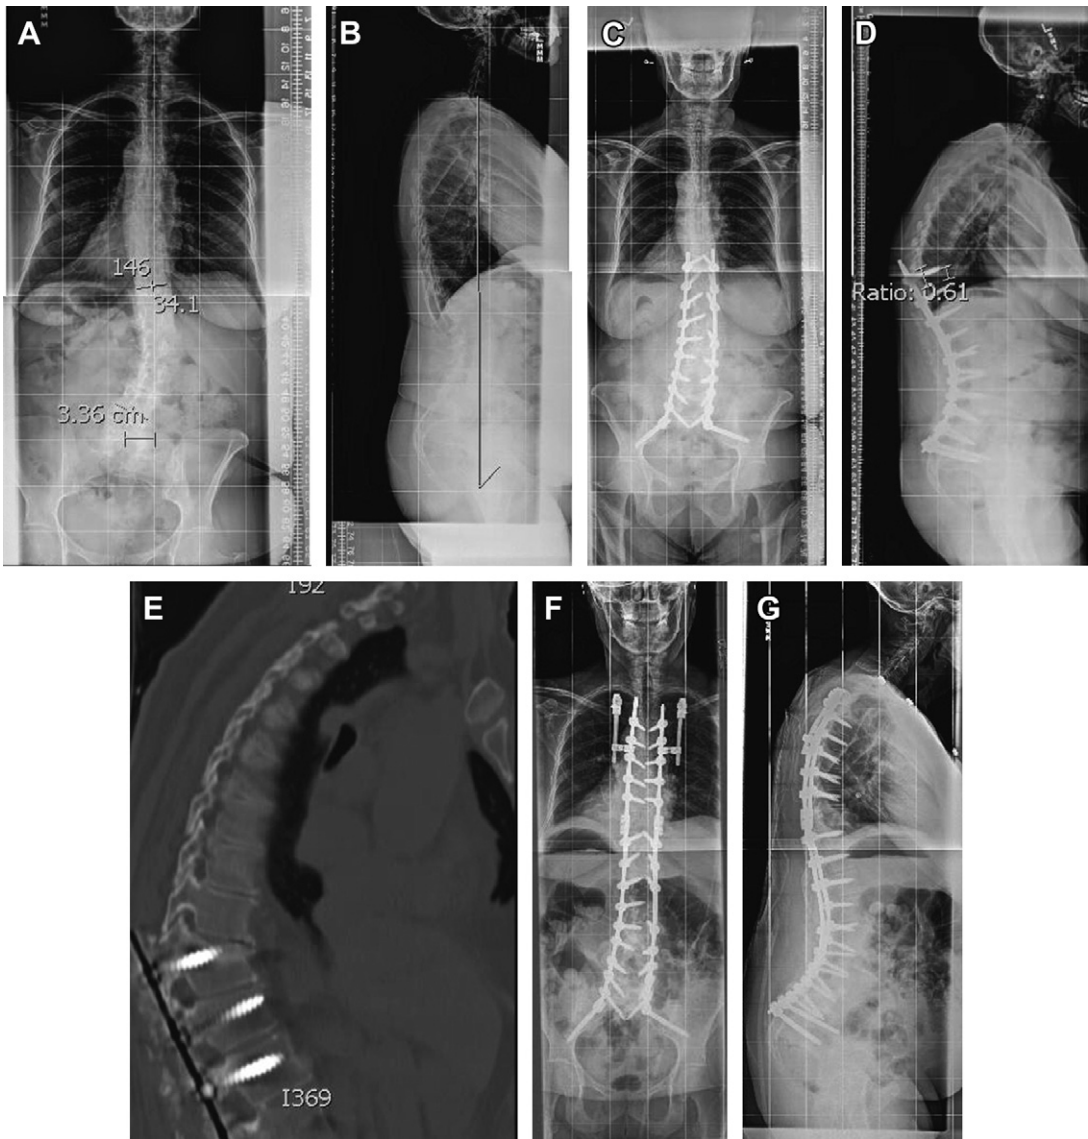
(A, B) Posteroanterior and lateral full length radiographs of a 61-year-old woman with progressive symptoms of spinal stenosis and scoliosis. There was no history of prior surgery, and bone density was normal. Preoperative lumbar lordosis is 68° , thoracic kyphosis is 65° , and junctional kyphosis (T8–T10) is 11° . Pelvic incidence measures 75° . (C–E) Six week postoperatively from T10–pelvis instrumented fusion with transforaminal lumbar interbody fusion at L4/5 and L5/S1, she demonstrated a fracture of T10 vertebral body with disruption of the posterior tension band, although nondisplaced. She was symptomatic with significant axial pain and was quite bothered by the junctional kyphosis. Immediate postoperative radiographs had shown lumbar lordosis of 79° (PI–LL = -4°), thoracic kyphosis of 71° , and junctional kyphosis of 16° . Thus her immediate postoperative films did not display PJK despite early reciprocal increase in thoracic kyphosis and good matching of lumbar lordosis to pelvic incidence. (F, G) At 3 months postoperatively she underwent extension of the fusion to T4 with a Smith-Petersen osteotomy at T9–10 and prophylactic rib fixation at T3 without fusion. Early postoperative results from her revision surgery have been encouraging.
